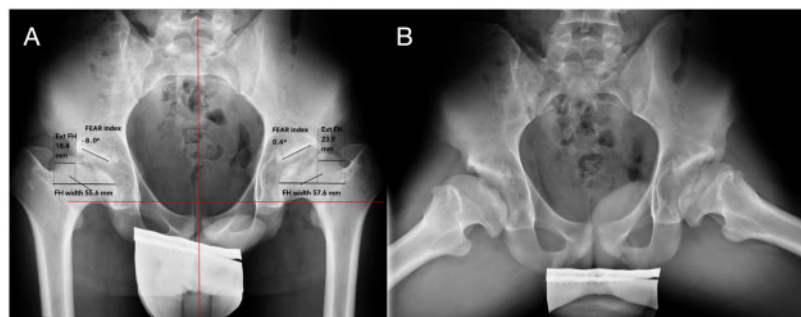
Pre-operative anteroposterior pelvic radiograph (A) and axial view of both hips (B). Widened, flattened and non-spherical femoral head, high-riding greater trochanter with negative artculo-trochanteric distance, short femoral neck and acetabulum under coverage. The extrusion index defined as the % of the femoral head (FH) width not covered by the acetabulum was 33.1 and 41.9% for the right and left hip, respectively. The Femoro-Epiphyseal Acetabular Roof (FEAR) index measured between the line of the acetabular roof and the central third of the physeal scar of the FH was -8° and 0.4° . The pelvis appears to be anteriorly rotated or anteverted due to the hip flexion contracture of the patient, which resulted in an apparent acetabular retroversion, inferred by the crossover sign and prominent ischial spines.
